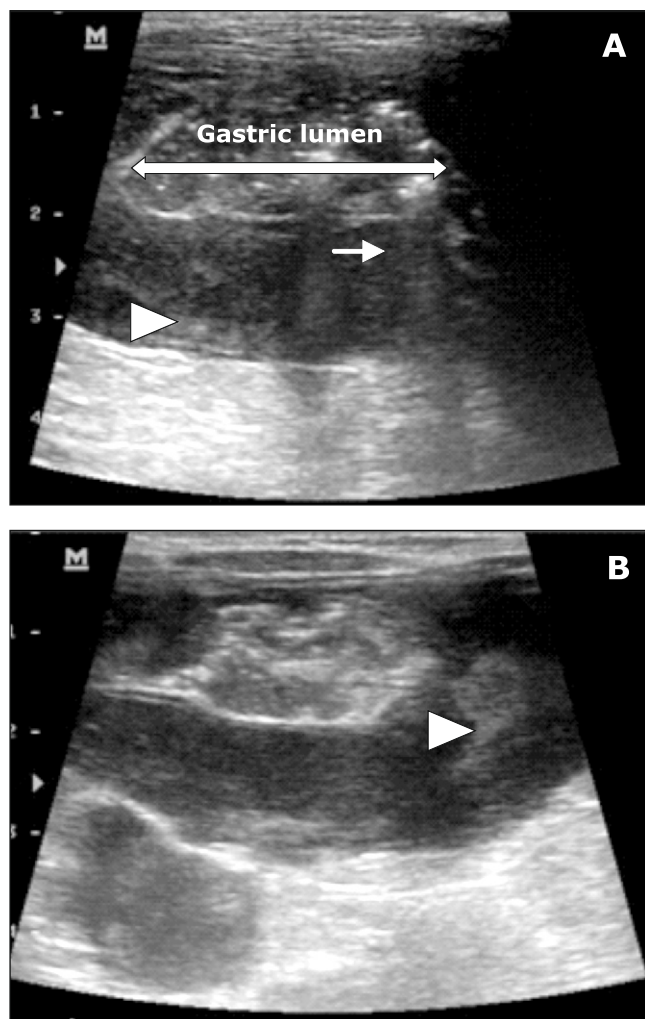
A. Transvers sonogram of the stomach. Hypoechoic aspect and hypertrophy of the gastric wall (arrow head). Presence of gas in the gastric lumen (arrow). 7.5 MHz linear transducer;
